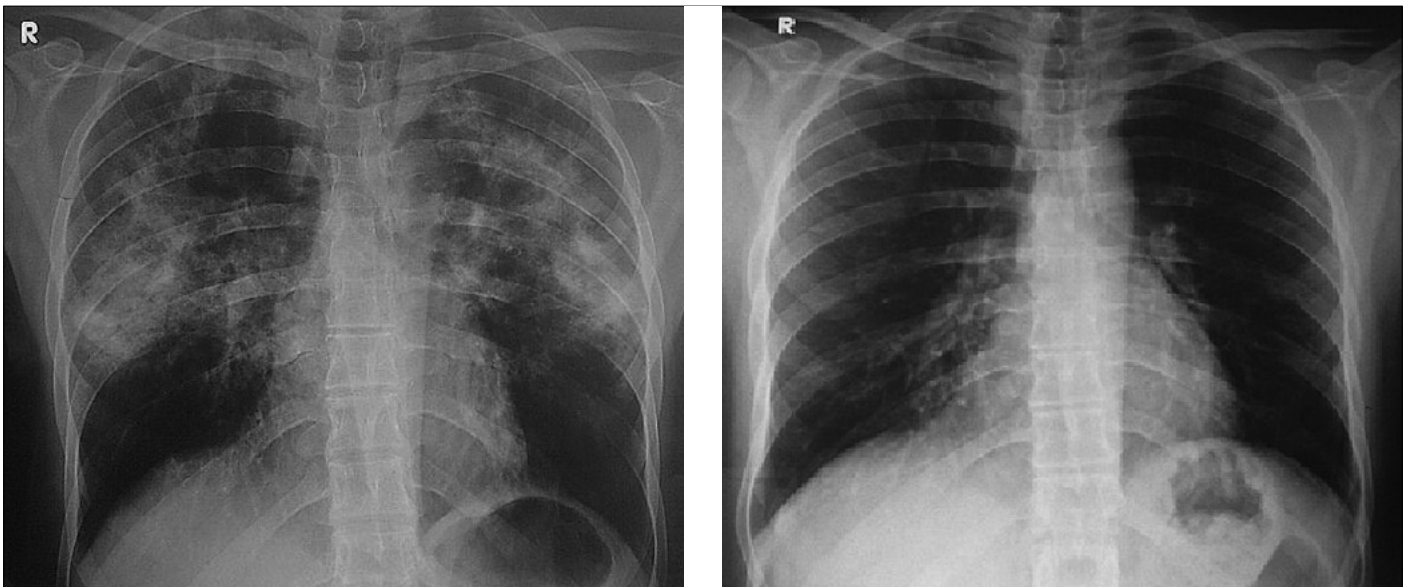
Case 2: Complete recovery was seen in infiltrates on the PA chest X-ray 1 week after the initiation of treatment with systemic steroids
